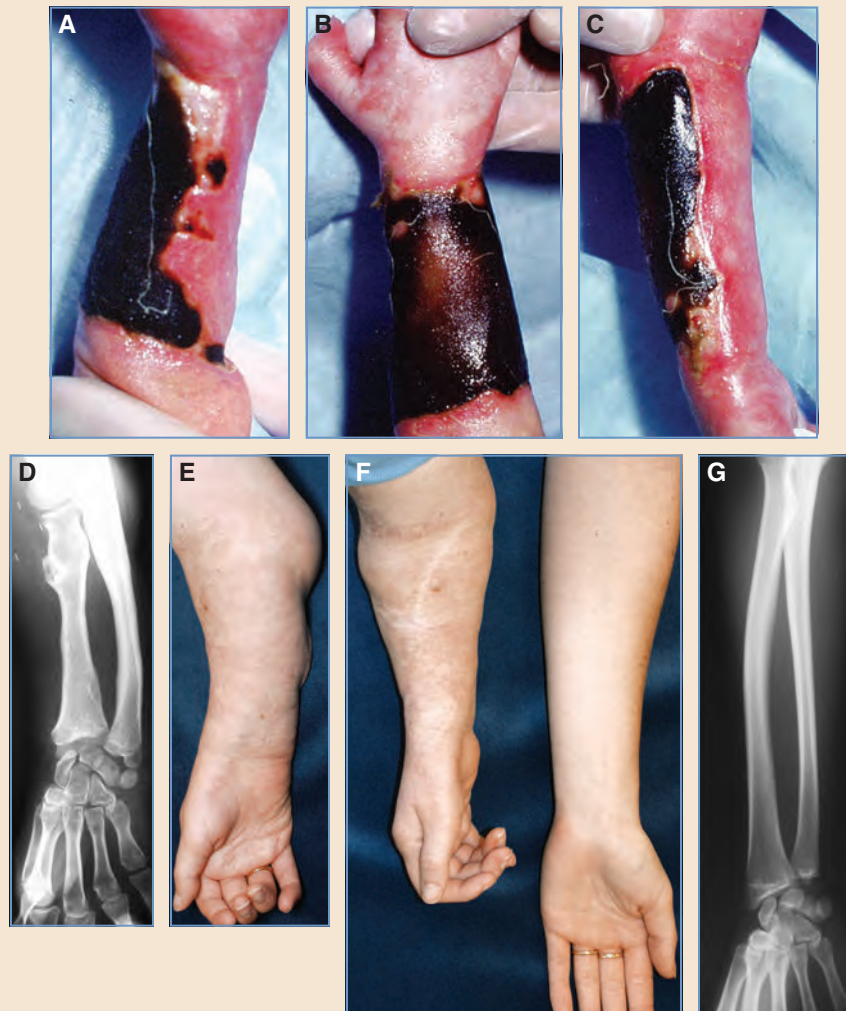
Type IV defect. A-C, This infant was born vaginally after a very difficult and prolonged labor. By 2 weeks of age, she had a full-thickness eschar. The mother had gestational diabetes and toxemia of pregnancy. The wound was debrided over the next 3 weeks, and the granulation bed was covered with a split-thickness skin graft by a pediatric surgeon. D-G, The clinical appearance and radiographs of the patient's right and left forearms and hands at 22 years of age. The reconstruction consisted of pedicled flap coverage of the entire dorsal forearm at 3 years of age, a free gracilis muscle transfer for wrist extension at 7 years of age, an osteotomy and lengthening of the radius at 9 years of age, and re-routing of the biceps tendon for correction of a fixed supination contracture. She has had normal sensation, intact radial and ulnar arteries, and tight flexor tendons for her entire life.
